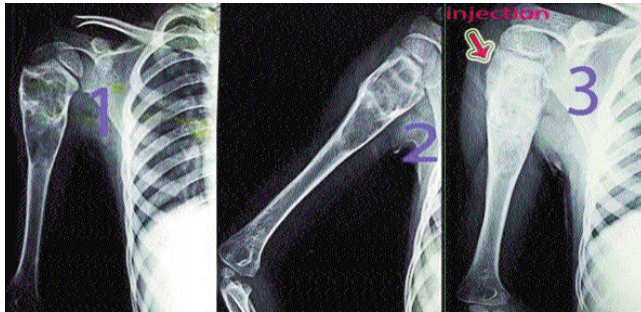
X-ray of a 11-year boy having unicameral bone cyst proximal humerus.
